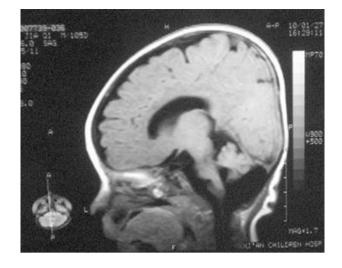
Magnetic resonance imaging showed enlarged lateral ventricles, cerebellomedullary cistern, epicele, and hydrocephalus, which were in compatible with features in Dandy-Walker syndrome
